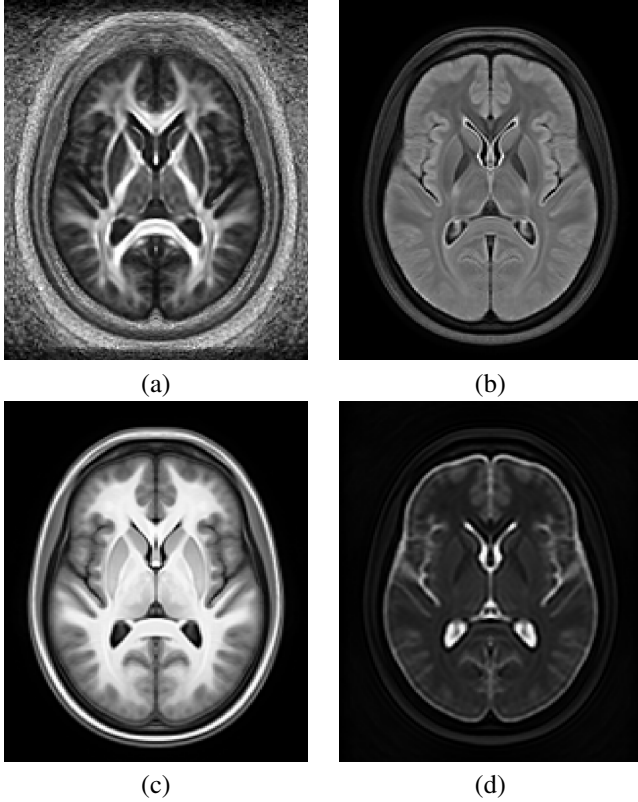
Multivariate symmetric template created from the Kirby 21 data described in [17]. Shown are the (a) fractional anisotropy (FA), (b) FLAIR, (c) MPAGE, and (d) T2 template components.
